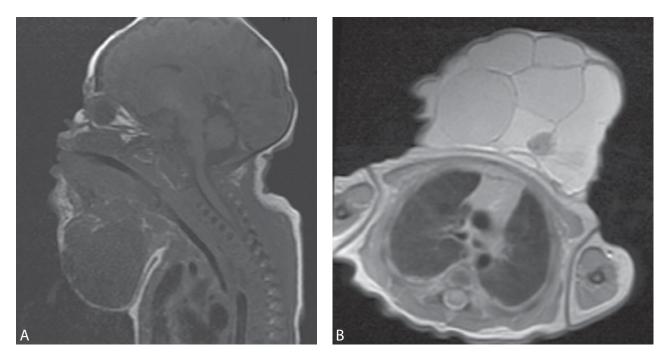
A and B. Postnatal MRI images demonstrating large submental cystic mass resting on the anterior surface of the fetal chest.
